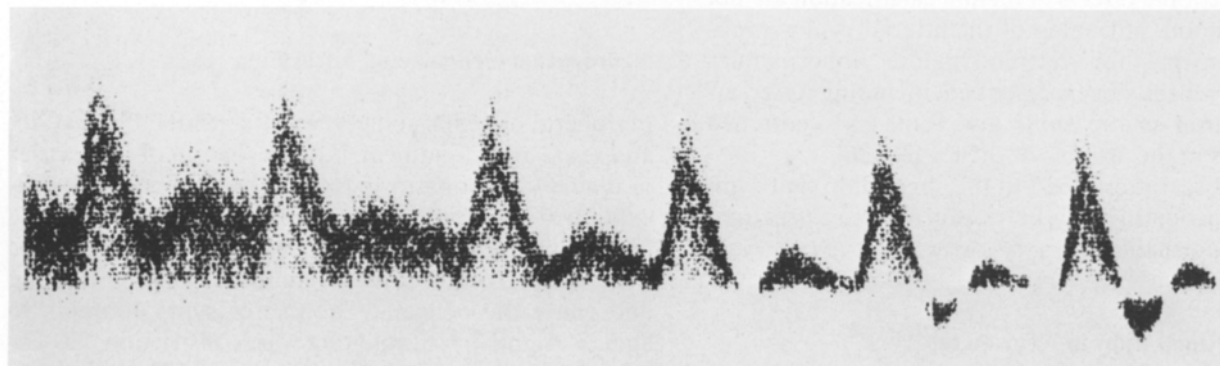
Doppler ultrasound sonogram from the posterior tibial artery of a young female patient with painful neuropathy. On the left, the pattern of the sonogram is that typical of neuropathy, showing the normal upward deflection of forward flow followed by continuous forward flow throughout diastole with complete loss of the expected reversed flow; after sympathetic stimulation (by coughing) the appearance of the sonogram becomes normal (on the right) showing the typical triphasic appearance – upward deflection of forward flow followed by reversed and later again forward flow in diastole. (A. G. Archer, unpublished observation)
